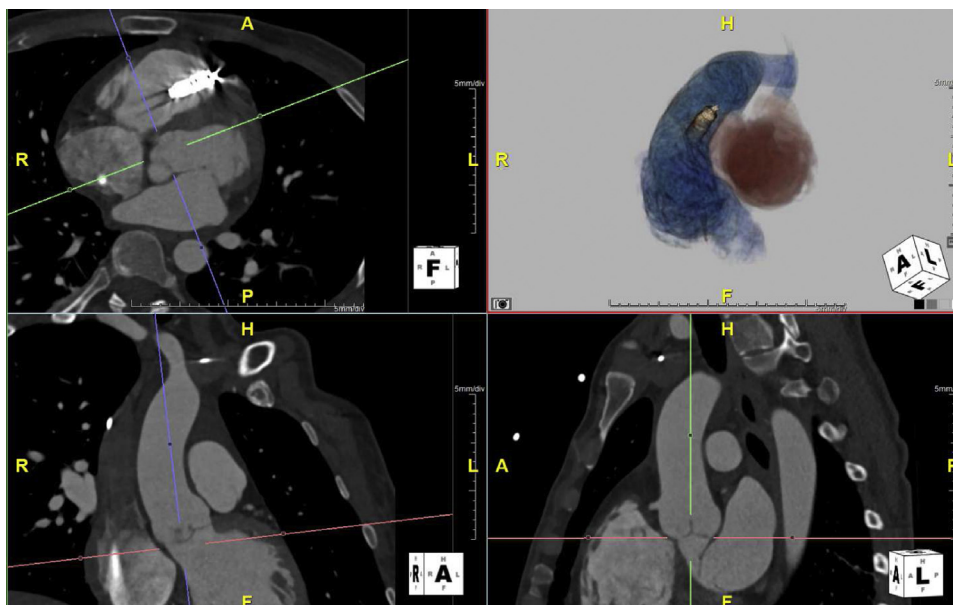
Pre-extraction chest computed tomographic scan. Three-dimensional reconstruction of the leadless pacemaker confirms its position in the right ventricular outflow tract.
